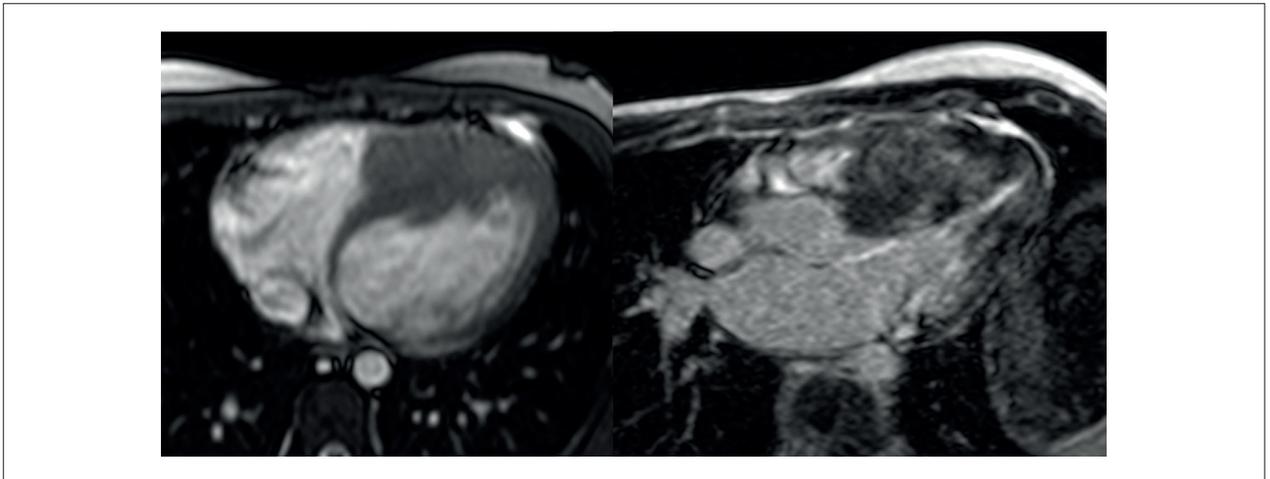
A 10-year-old asymptomatic patient, with increased thickness of the interventricular septum. His father had been diagnosed with hypertrophic cardiomyopathy and was on the waiting list for a heart transplant. MRI showed ventricular hypertrophy with the appearance of a mass in the middle and apical portions of the interventricular septum. Delayed enhancement images showed predominance in areas of hypertrophy in the 3-chamber view. Together, these findings are suggestive of hypertrophic cardiomyopathy with a pseudotumoral pattern.
